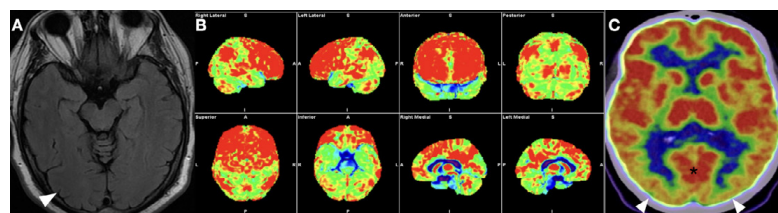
(A) Axial T1-weighted MR imaging in a patient with DLB demonstrates normal cerebral volume, including the occipital lobes. (B) 18F-FDG-PET demonstrates cortical hypometabolism involving both occipital lobes with sparing of the posterior cingulate gyri. (C) Axial 18F-FDG-PET image demonstrates hypometabolism affecting the occipital lobes (white arrows) with relative preservation of the posterior cingulate gyri (black asterisk), producing the “posterior cingulate island” sign.
